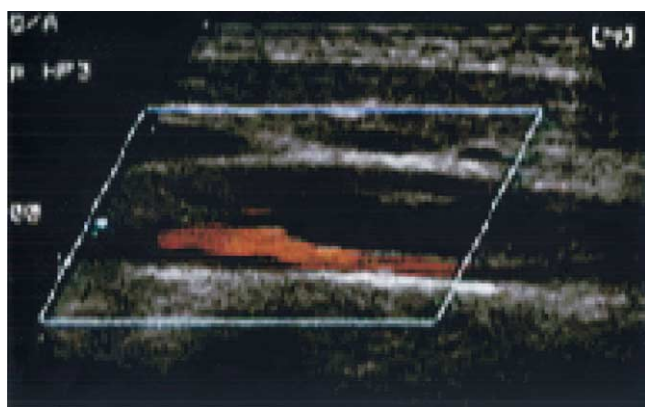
Duplex carotid echocardiogram showing compression of the true lumen by the false lumen in the right carotid artery.
